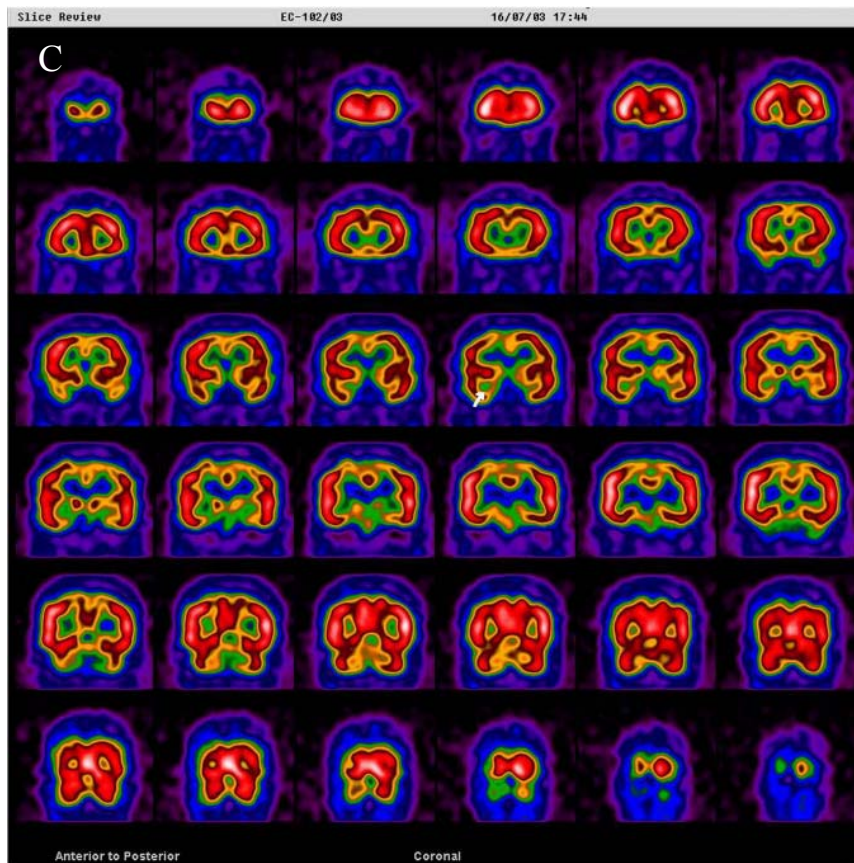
Continued. C: Preoperative interictal SPECT showing hypoperfusion area in the right hippocampal region (arrow).
